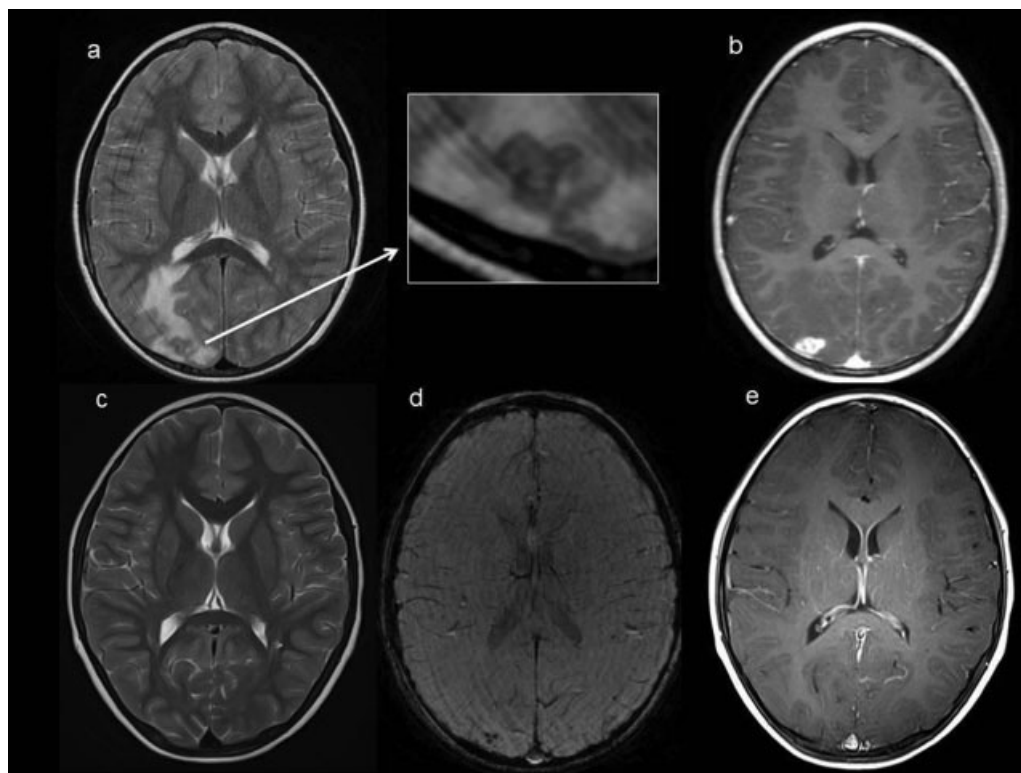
Case 3. (a) T2-weighted magnetic resonance imaging (MRI) at presentation showing two confluent small cysts in the right occipital lobe, of which at least one showed a possible scolex. (b) T1-weighted MRI with gadolinium at presentation showing enhancement of the lesion. (c) T2-weighted MRI 3 months later showing clear reduction of the lesion. (d) Susceptibility weighted MRI at follow-up showing calcification of the lesion. (e) T1-weighted MRI with gadolinium at follow-up showing clear reduction of the lesion.
